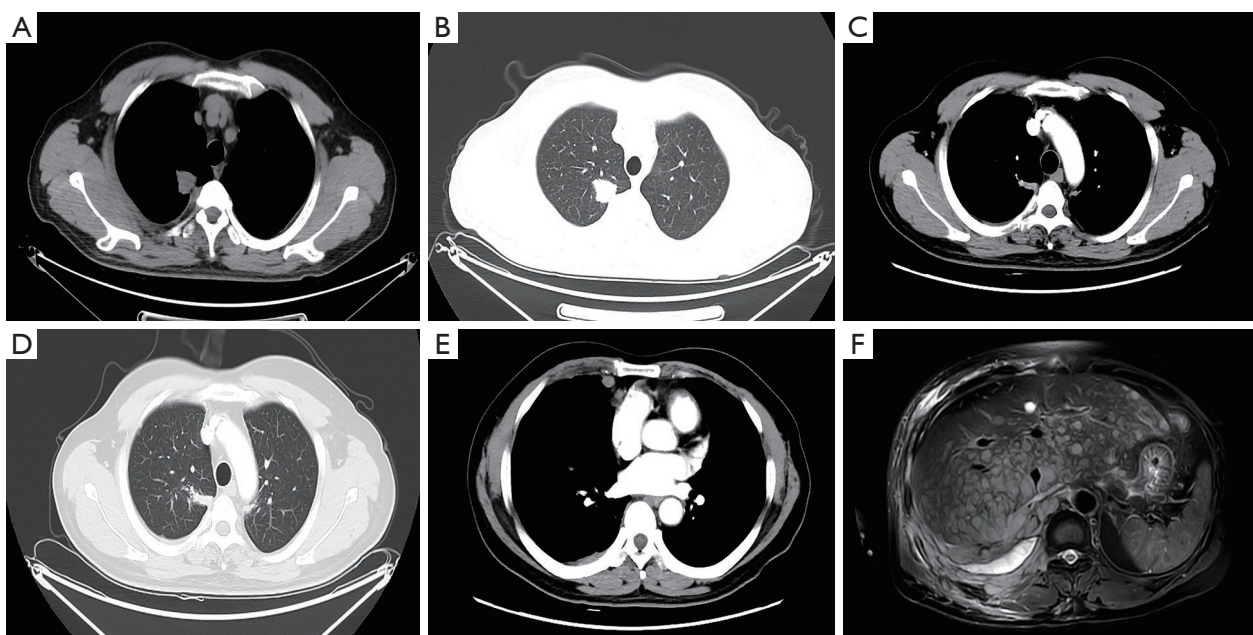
Images of case 4 at initial diagnosis and after transformation. (A) Chest CT in mediastinal window at initial diagnosis (adenocarcinoma). (B) Chest CT in pulmonary window at initial diagnosis (adenocarcinoma). (C) Chest CT in mediastinal window after transformation (SCLC). (D) Chest CT in pulmonary window after transformation (SCLC). (E) CT manifestations of pleural metastases after transformation (SCLC). (F) MRI manifestations of liver metastases after transformation (SCLC). CT, computed tomography; SCLC, small cell lung cancer; MRI, magnetic resonance imaging.
